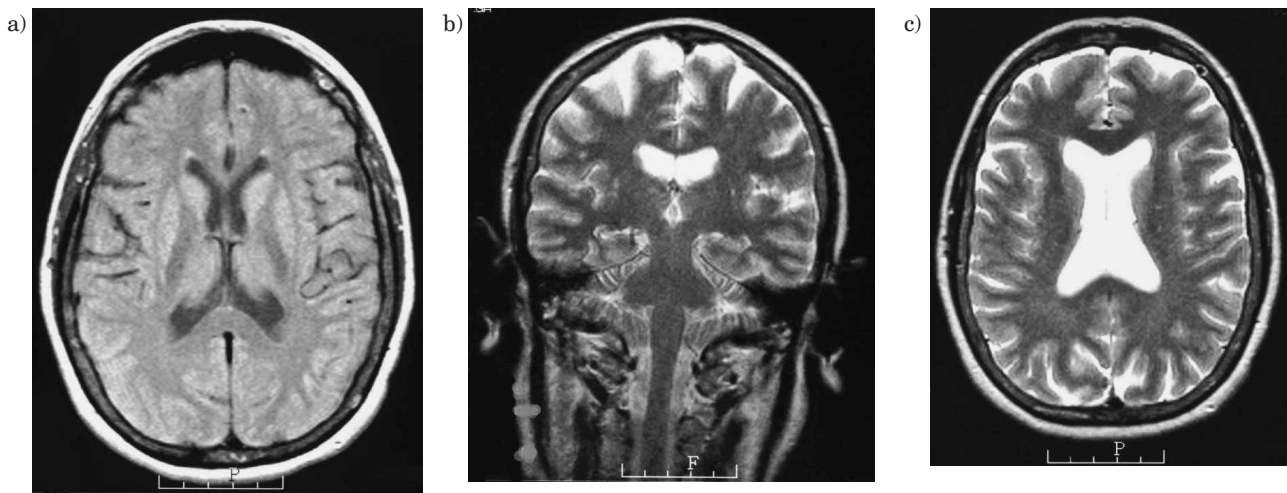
a) Transverse T2-weighted MRI with serious cortical atrophic changes especially parietotemporal with dilatation of occipital horns. b) Coronal T2-weighted MRI of the same patient as on Fig. 3a. c) Transverse T1-weighted MRI of the same patient as on Fig. 3a and 3b.
